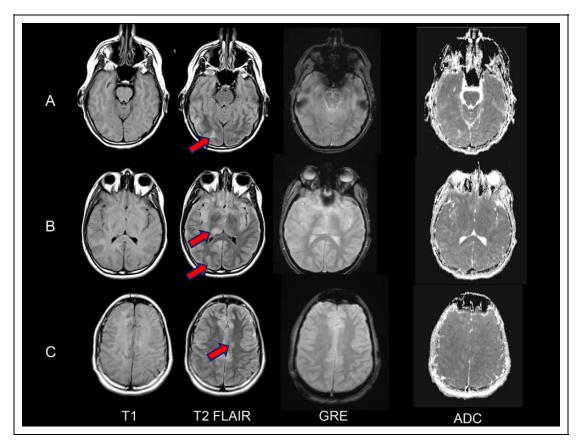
Neuroimaging findings. MRI scan of the brain revealed diffuse signal abnormalities within the subcortical white matter, thalamus, and basal ganglia. TI-weighted, T2 FLAIR, gradient echo sequence, and ADC images at the level of midbrain (A), basal ganglia (B) and centrum semiovale (C). Bilateral asymmetric foci of increased T2-signals are demonstrated (arrows) involving the thickened cortices, thalami, and globus pallidi but sparing the posterior fossa structures (not shown), brainstem or centrum semiovale. Gradient echo sequence images showed no hemorrhagic areas. The areas of T2-prolongation did not show diffusion restriction or contrast enhancement (not shown).
